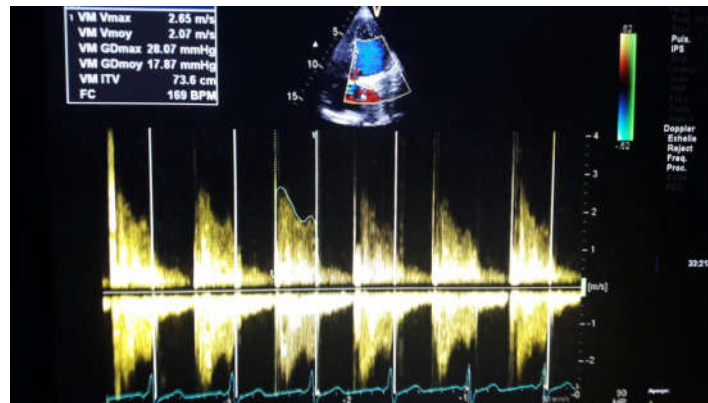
Transthoracic echocardiography showing a mechanical prosthesis in the double-finned mitral position with a blade lock, with a mean gradient at 17mmHg
